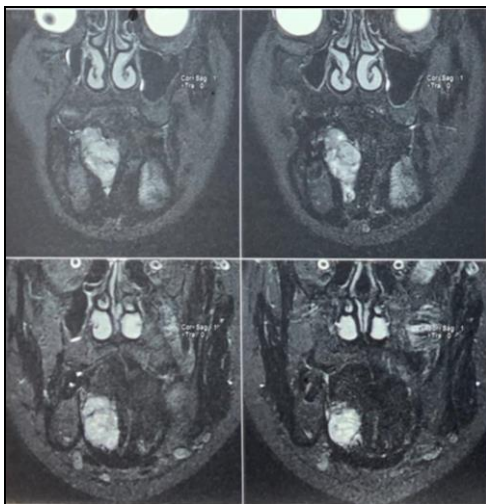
Coronal MRI showing a well-defined, heterogeneous mass of the floor of the mouth, extending towards the submandibular space, consistent with adenoid cystic carcinoma.
